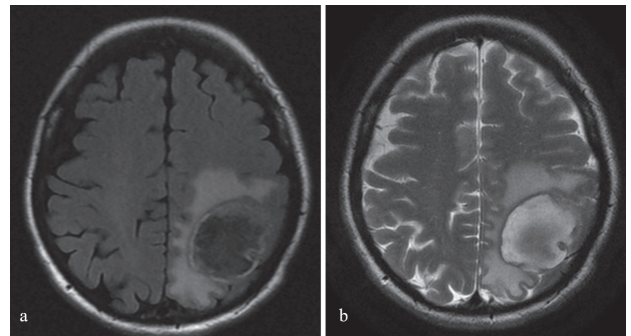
Axial FLAIR (a) and T2WI (b)
